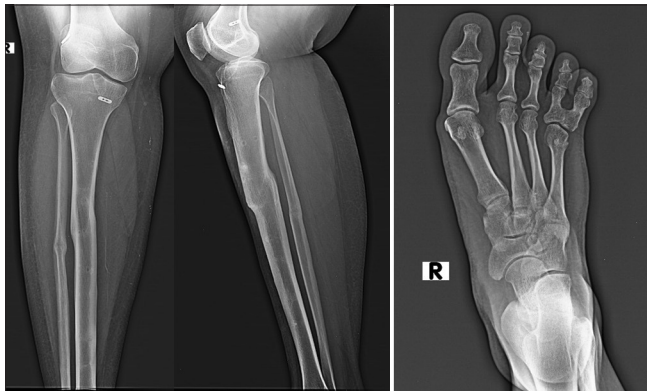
X-ray after removal of the Ilizarov frame and union of the osteotomy site showing the corrected alignment of the leg. Note the Endobutton used for ACL repair. X-ray showing corrected deformity of the toes. ACL: Anterior cruciate ligament
